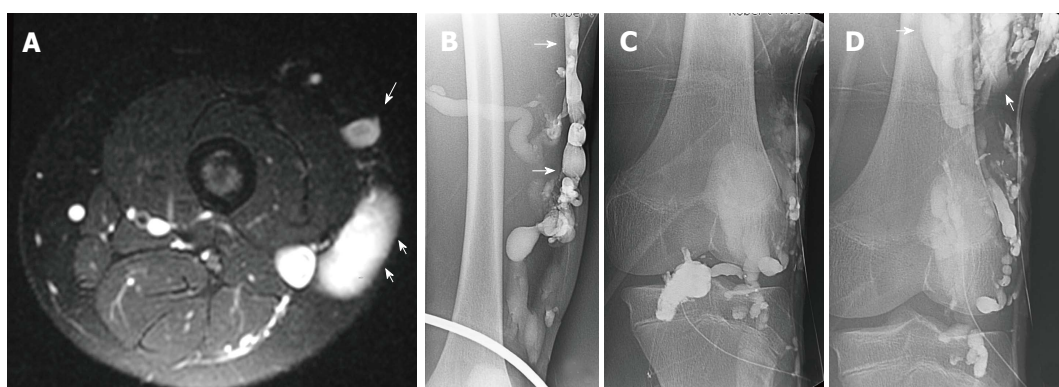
Klippel Trenaunay Syndrome. Axial T2 weighted fat suppressed magnetic resonance image of the thigh (A) in a patient with Klippel Trenaunay syndrome demonstrates a lateral embryonic vein (arrows) and venous malformation (short arrows). Lower extremity venogram demonstrates the lateral embryonic vein (arrows) (B). Direct puncture venography prior to alcohol sclerotherapy demonstrates progressive filling of the low flow truncular venous malformation (arrows) (C, D).
